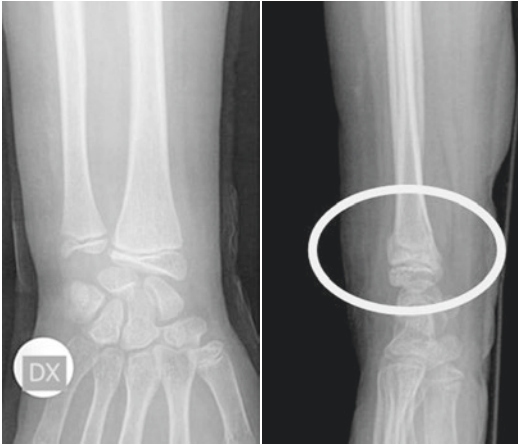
Plain radiograph shows fracture of distal radial epiphysis in child in lateral projection (white circle)
